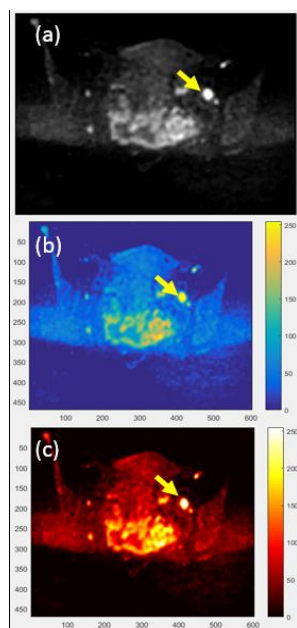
PLN in DW-MR image. (a) DW-MRI with metastatic PLN (yellow arrow). A PLN in a patient with cervical cancer has a bright intensity in DW image. Metastatic PLNs appear with a higher intensity than benign PLNs and it is therefore advantageous to use this sequence for classification. (b) DW image scaled to full range of colors. (c) DW image scaled to full range of hot colors.
